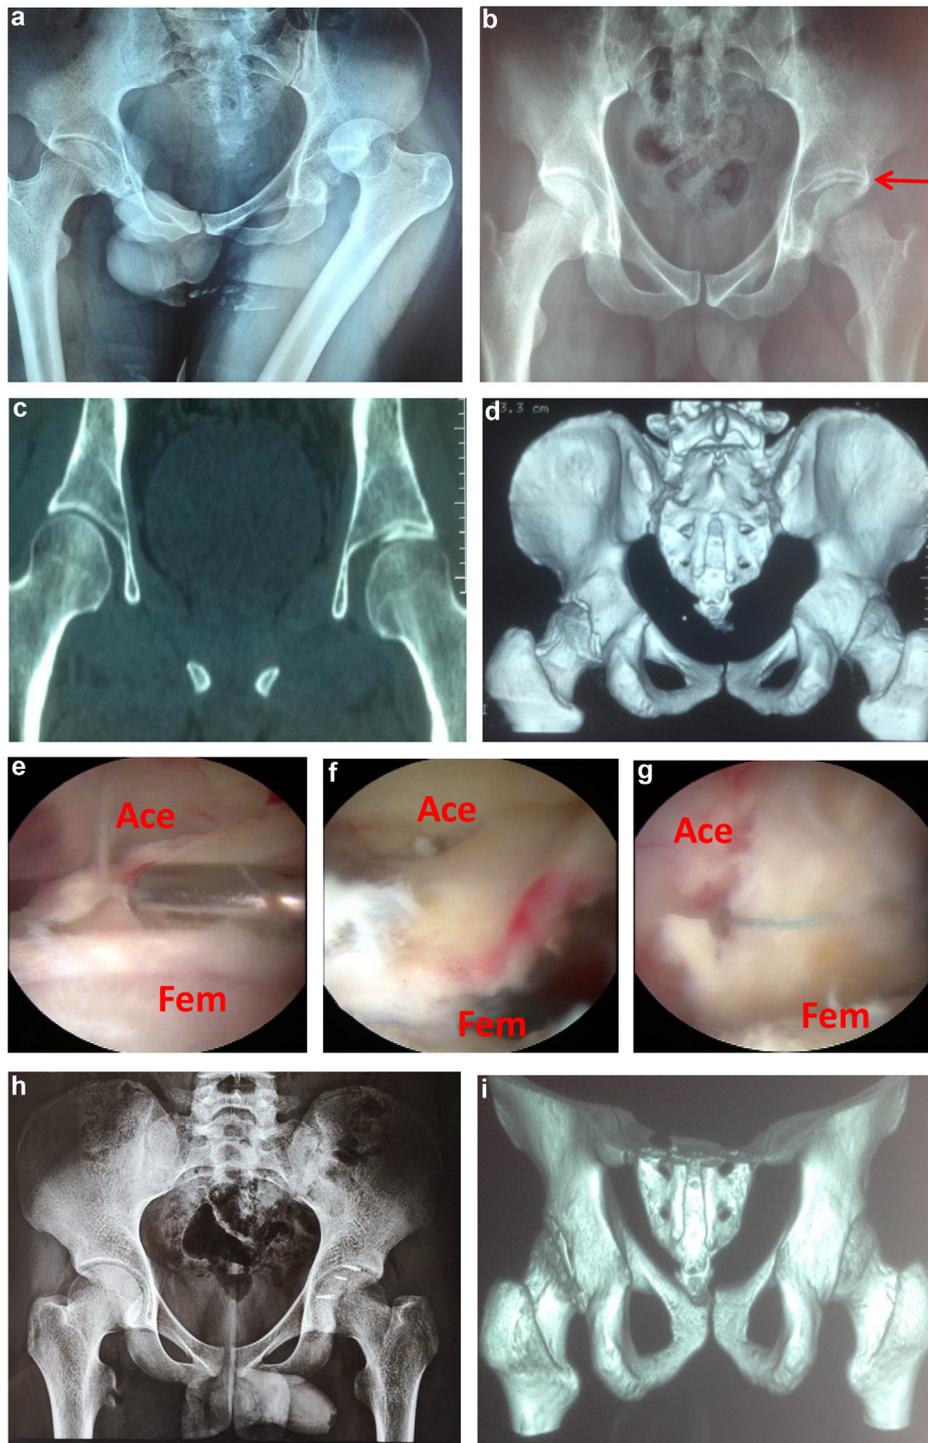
A typical case of nonconcentric reduction of hip posterior dislocation: a: showed left hip posterior dislocation; b: showed nonconcentric joint with a bone fragment; c: CT showed entrapment of a bone fragment in joint; d: 3-dimensional CT confirmed the bone fragment come from the posterior wall of the acetabulum; e and f: the labrum bony bankart lesion was showed under arthroscopy; g: the image of labrum rim fracture after reduction and fixation; h: postoperative X-ray showed concentric joint.; i: CT showed anatomical reduction of labrum rim fracture. A: acetabulum; F: femoral head.
